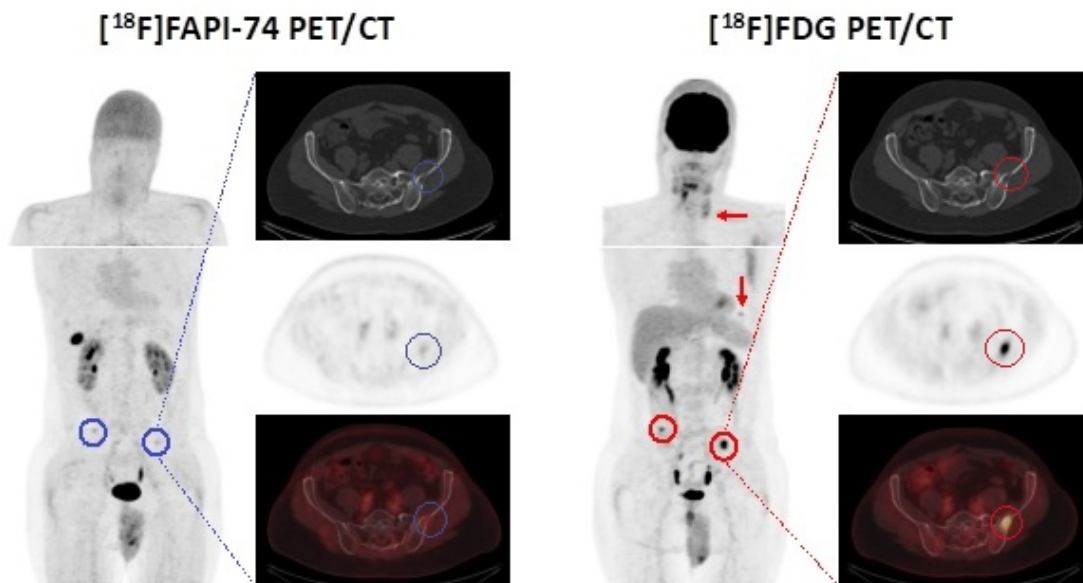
Maximum-intensity projection (MIP) and axial ^{18}F -FAPI-74 PET/CT (A) showed low uptake in two bone metastases (blue ring): Computed tomography with a lytic lesion in left Os ileum, ^{18}F -FAPI-74 PET and fused image with minimal uptake. Physiological ^{18}F -FAPI-74 uptake in the gall-bladder next to the right kidney. Maximum-intensity projection and axial ^{18}F -FDG PET/CT (B) demonstrated high uptake in the two bone lesions (red rings) and two additional bone metastases not detected in ^{18}F -FAPI-74 PET/CT (red arrows).
